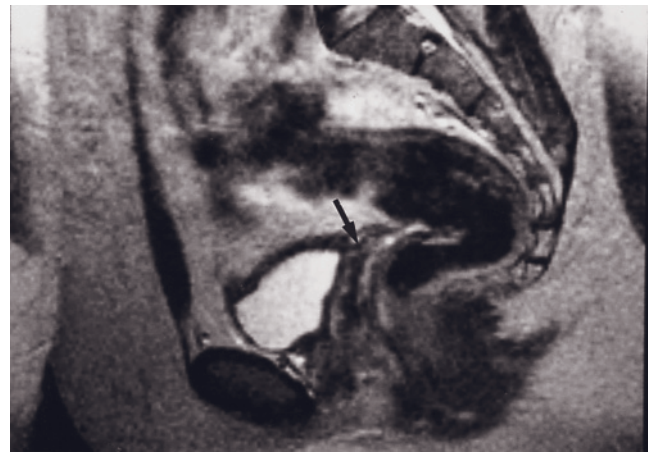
Testicular feminization. Sagittal T2-weighted echo-train spin-echo image. Note absence of the uterus and the blind-ended vagina (arrow).
